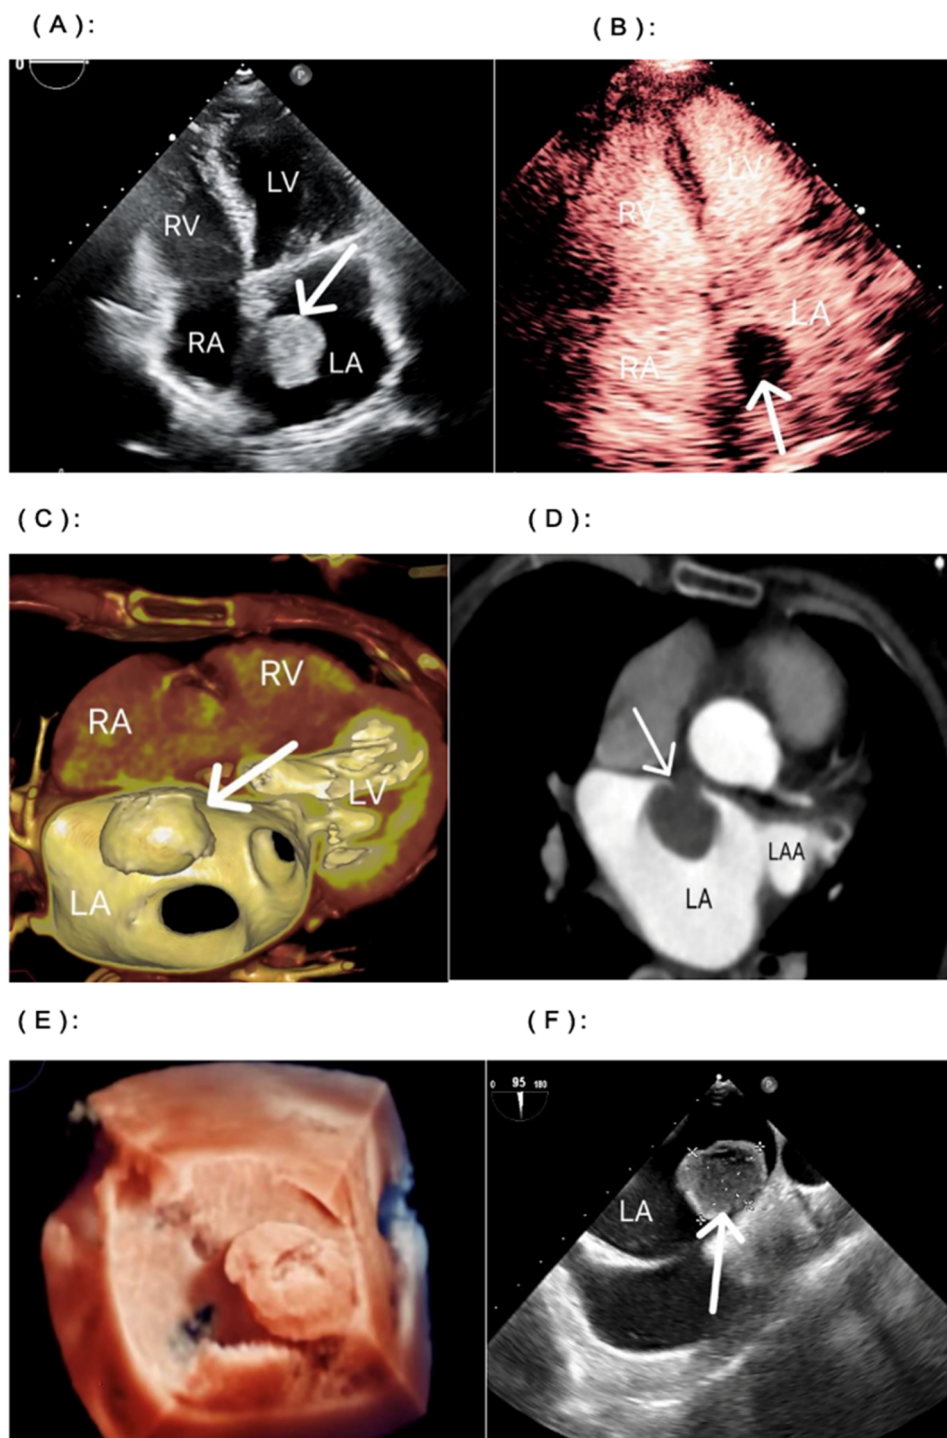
A: TTE Demonstrated a mass of unknown origin; B: Left heart contrast echocardiography showed a filling defect of the left atrium; C-D: CTA showed a mural mass in the left atrium, attached to the anterior wall; E: Three-dimensional echocardiography identified the diagnoses of thrombus; F: TEE revealed the location and size of thrombus (from reference [39]).
